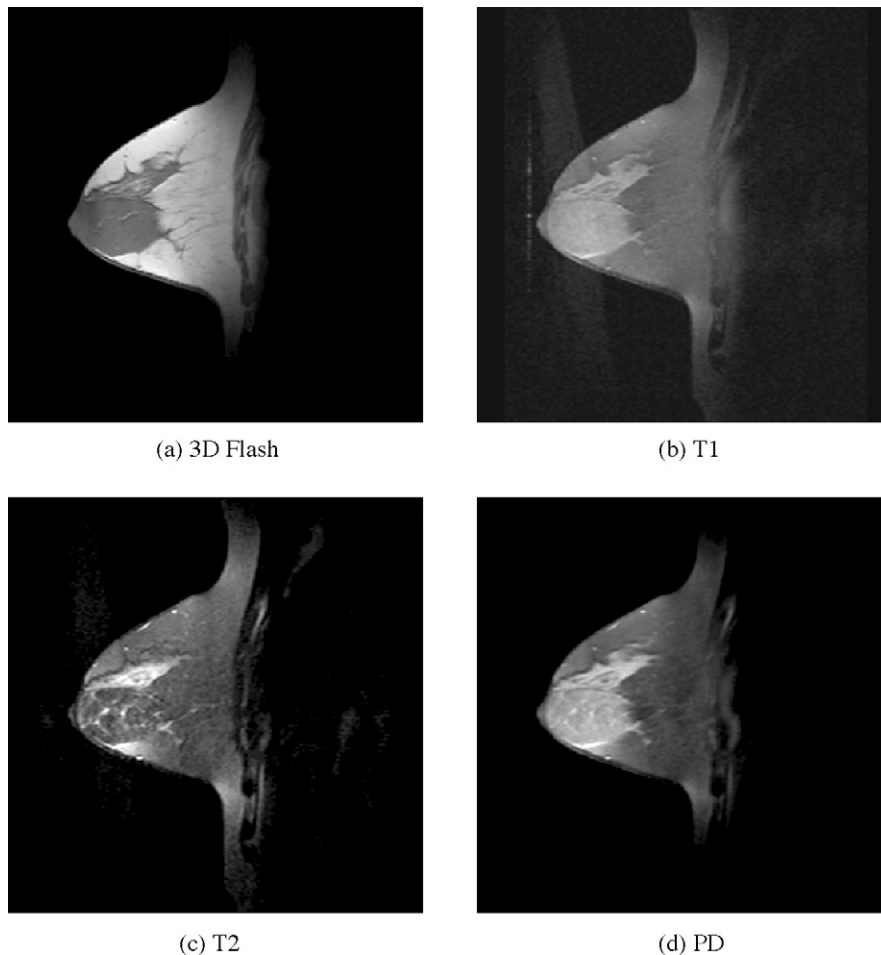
Four bands of real breast MRIs. (a) Three-dimensional fast low-angle shot (3D Flash) gradient echo sequence (TR/TE = 12/5 ms, flip angle = 25°, matrix = 512 × 179), (b) sagittal image from fat-saturated T1-weighted turbo spin-echo (TR/TE = 832/20 ms, flip angle = 90°, matrix = 512 × 152), (c) T2-weighted fat-saturated image (TR/TE = 3000/105 ms, flip angle = 90°, matrix = 512 × 154), and (d) proton density fat-saturated image (TR/TE = 3000/15 ms, flip angle = 90°, matrix = 512 × 154).
